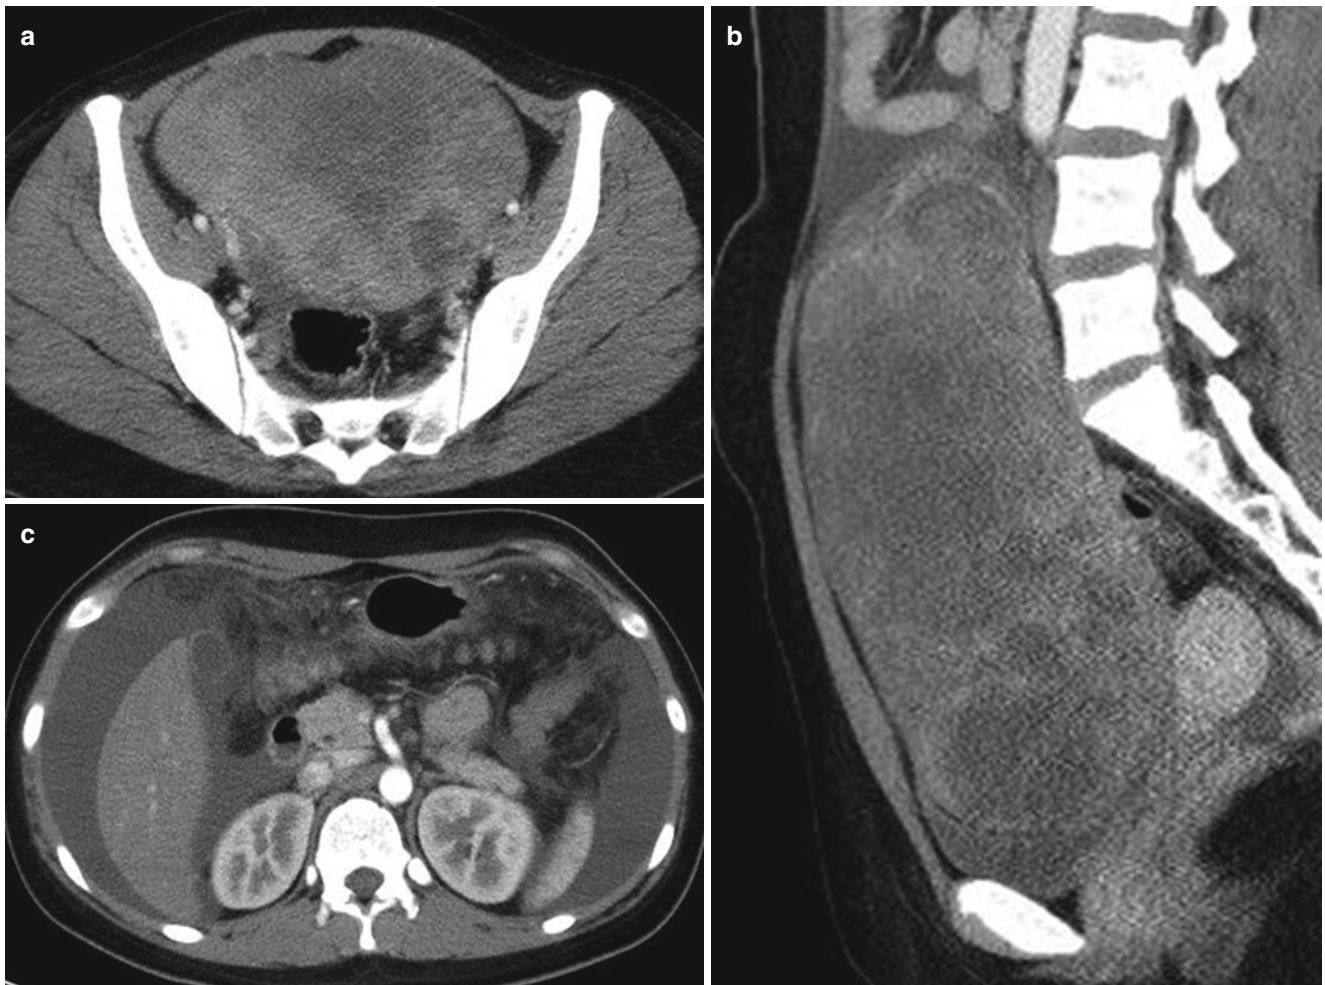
Dysgerminoma of left ovary in a 15-year-old girl. (a, b) Contrast-enhanced axial and sagittal CT scans show a large solid enhancing mass in pelvic cavity. The mass has multifocal low-attenuation areas. (c) Contrast-enhanced axial CT scan of upper abdomen demonstrates large amount of ascites and ill-defined increased attenuation of omentum, suggesting peritoneal seeding
